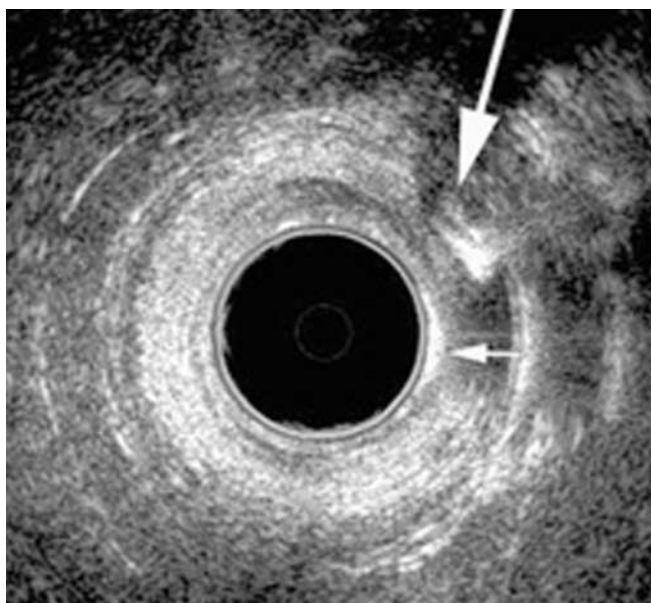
Endosonograms of an internal anal sphincter defect. a Transverse 2D view shows a 2-o'clock to 5-o'clock interruption of the internal anal sphincter. b Longitudinal projection (frontal section) of the anal canal: the cephalad-caudal extension of the sphincteric defect is more clearly seen
